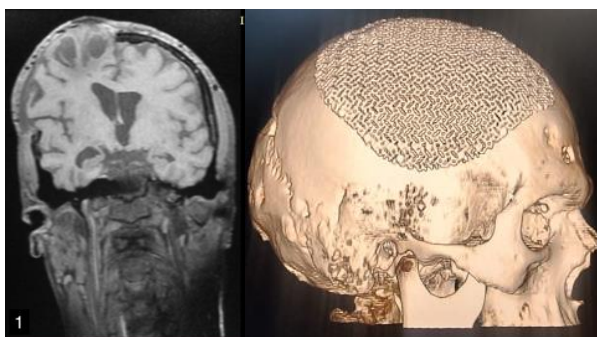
1 - Brain MRI revealing fungus cerebri (transcalvarial herniation of the cerebral parenchyma) through the craniectomy defect. 2 - CT scan status post right frontoparietal cranioplasty (6 months later).
